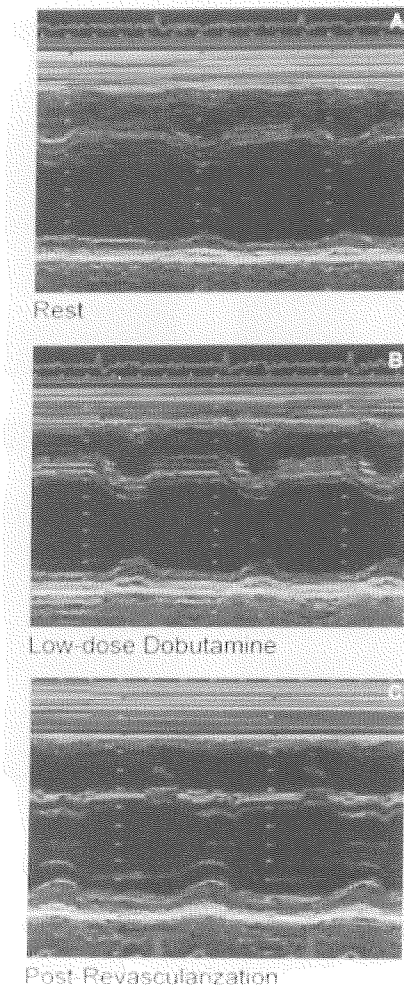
Example of post-revascularization improvement of posterior wall thickening as predicted by low-dose dobutamine stress echocardiography. M-mode tracings of the parasternal long axis view demonstrate at rest severe hypokinesia of the posterior wall (panel A). At low-dose dobutamine infusion wall thickening improved (panel B), after successful revascularization wall thickening at rest recovered to the level as predicted by low-dose dobutamine infusion.
